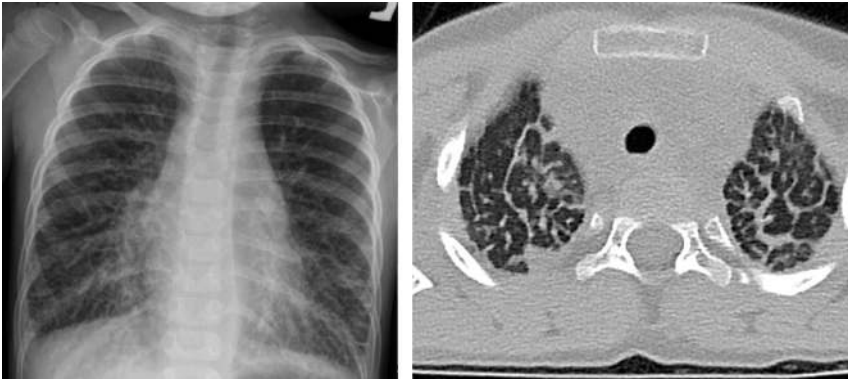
Chest radiograph and chest CT of a patient with KLA shows increased interstitial markings.
